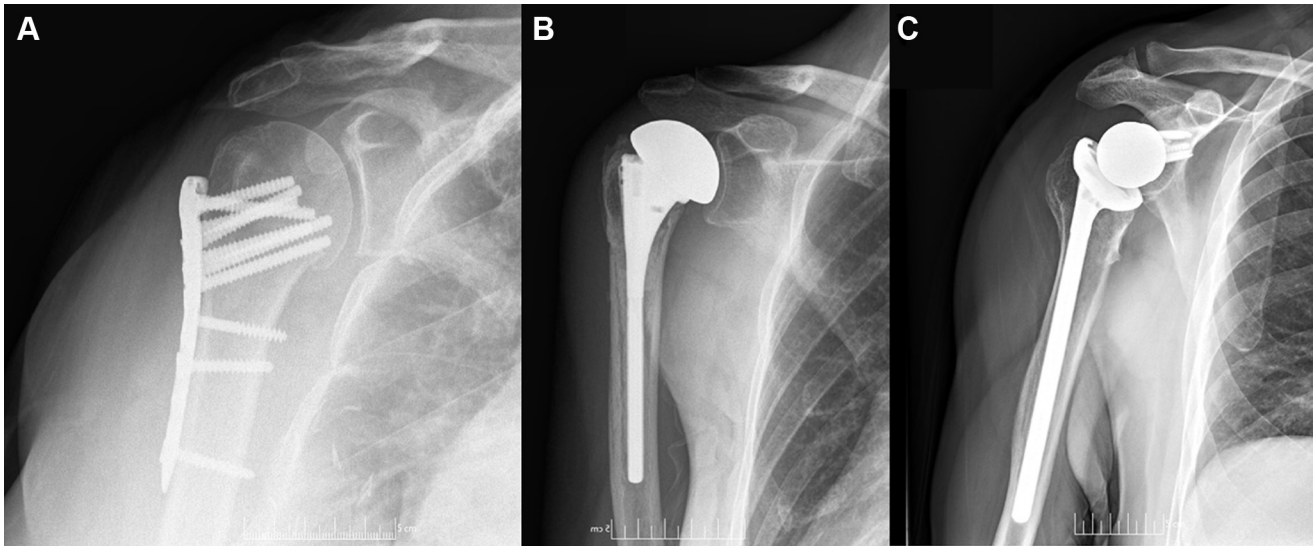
Examples of successful reconstruction. (A) 57-year-old woman's 14-month status after open reduction internal fixation for a 3-part proximal humerus fracture with radiographic union. (B) 57-year-old man's 6-month status after hemiarthroplasty for a 4-part proximal humerus fracture with union of the greater tuberosity. (C) 74-year-old man's 3-year status after reverse shoulder arthroplasty for a 4-part proximal humerus fracture with union of the greater tuberosity.
